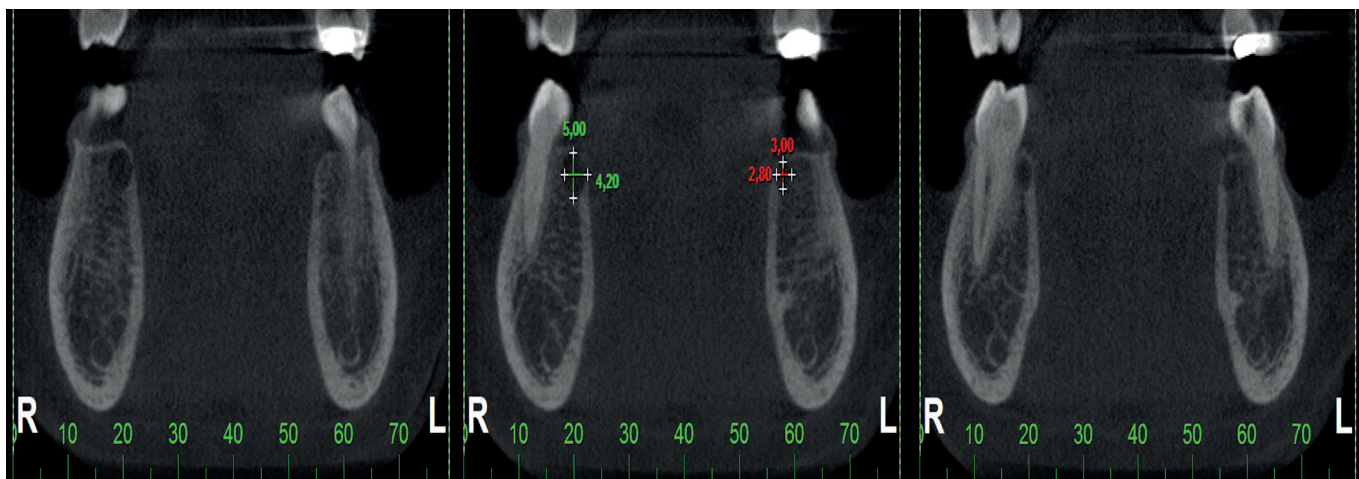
Coronal slices of CBCT highlighting the lingual position of the lesion, a mild resorption of mandibular right bone cortical and no bone displacement. A symmetric minor radiolucency in the left mandible was also observed.
